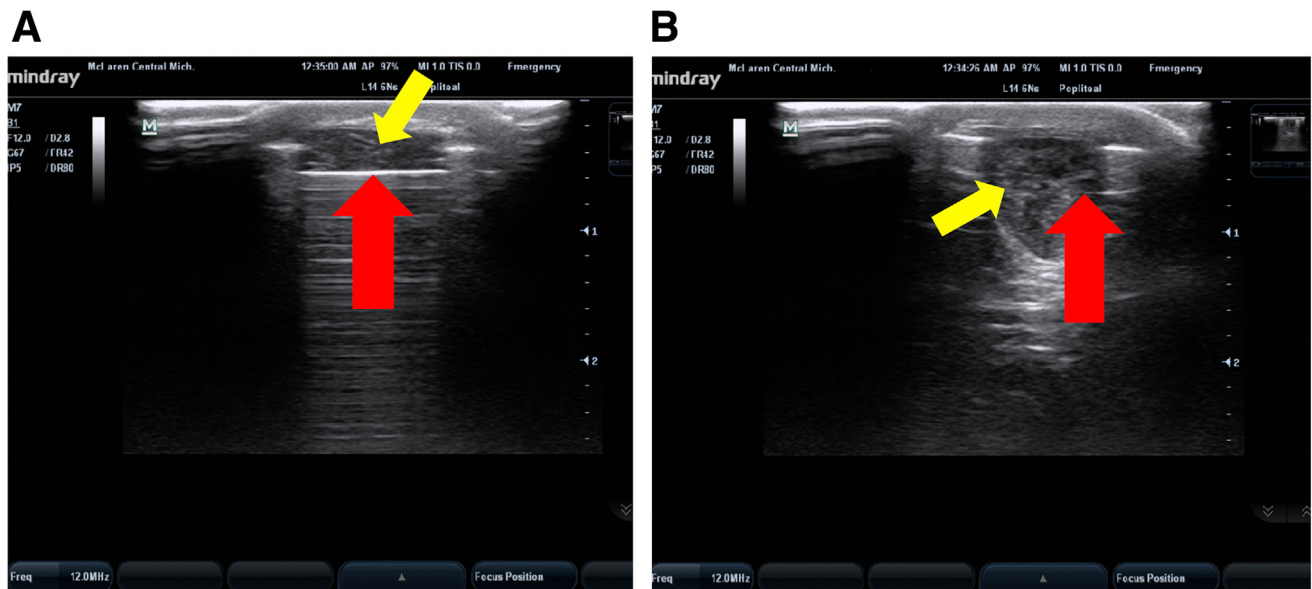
Short-axis intraoperative ultrasound imaging of Percutaneous Achilles Repair System (PARS) needle (red arrow) placement through the Achilles tendon (yellow arrow). The ultrasound probe is positioned over the posterior aspect of the ankle, overlying the Achilles tendon, at the level of the ankle surrounding the Achilles injury. (A) The PARS needle is visualized in appropriate position through the more proximal aspect of the Achilles tendon. (B) The PARS needle is visualized in appropriate position through the more distal aspect of the Achilles tendon.
